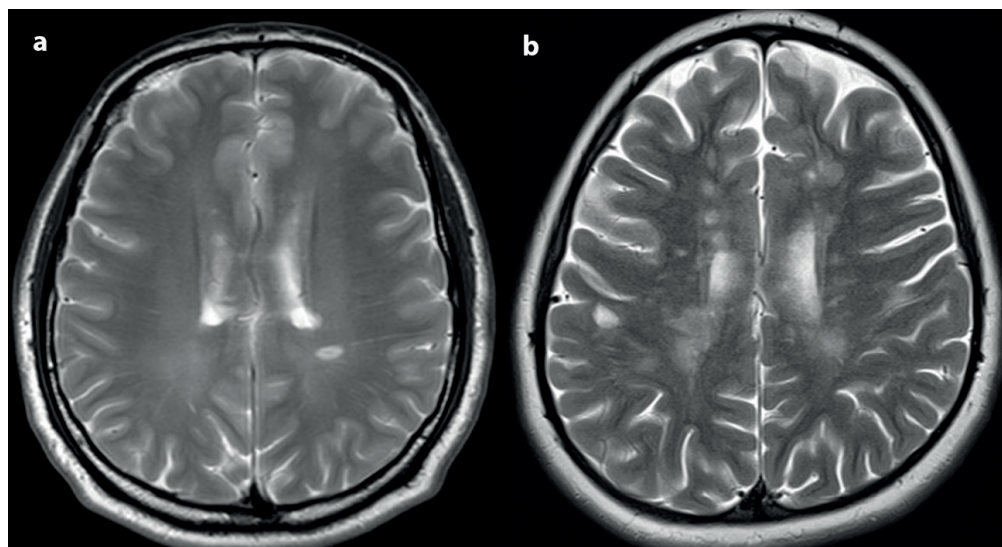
a, b. Axial T2-weighted MR images (a, b) show example of different T2 lesion burdens in two different patients with multiple sclerosis which have a same EDSS=5.
